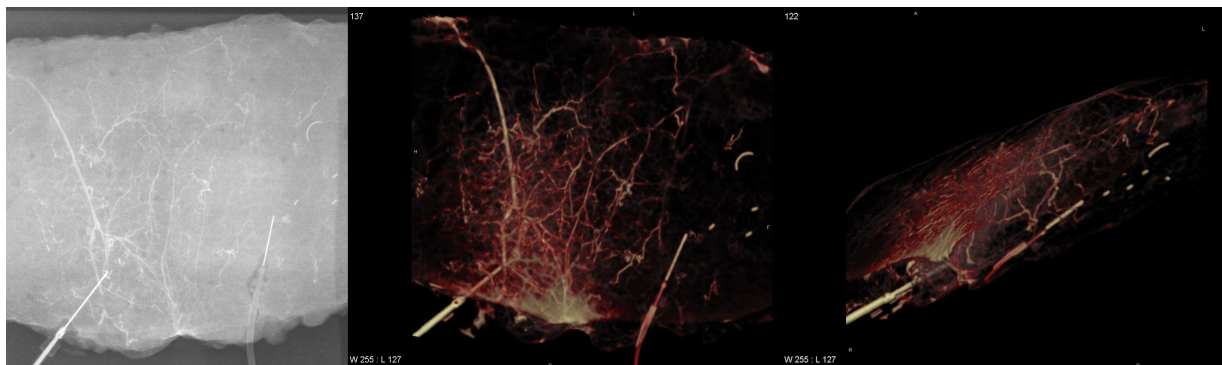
Iodinated contrast medium was injected in a perforator prior to conventional X-ray (left) and CTA examination of the flap (middle and right).
